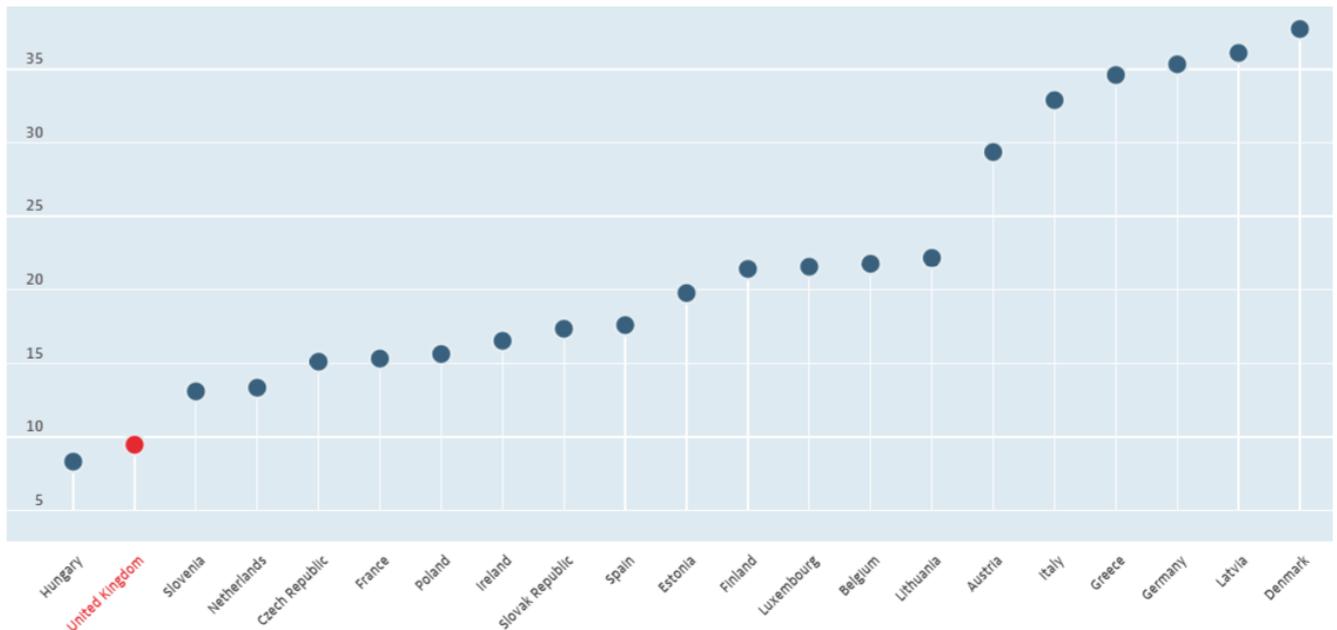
CT Scanners per 1,000,000 people in 2014 (OECD)(18)
